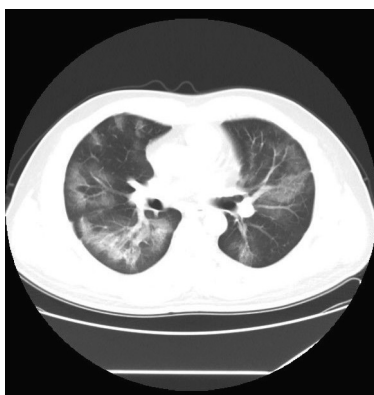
Chest CT, February 13,2020 (Illness Day 19, Hospital Day 16). Multiple ground-glass opacification in both lungs, more than 75% of the lungs were involved.
